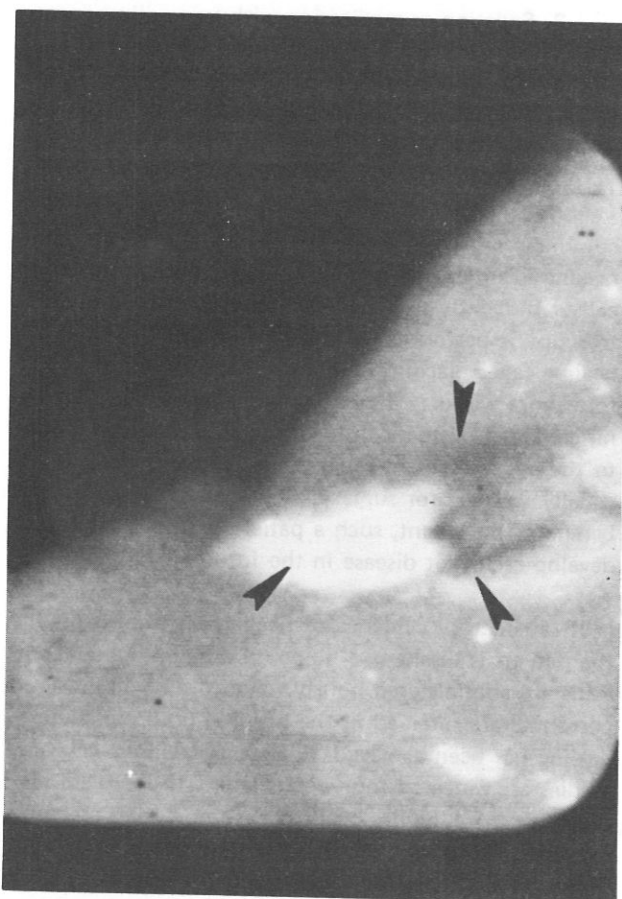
The lesser curvature gastric ulcer demonstrated radiographically in Figure 2 is seen on gastrosocopy to be a punched out lesion just proximal to the veil-like angularis incisura.
